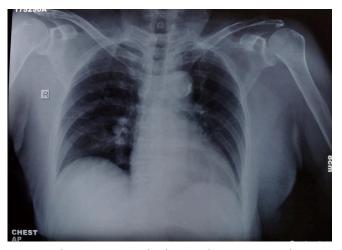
Shoulder radiographs showing the bilateral glenohumeral joint post-reduction.
